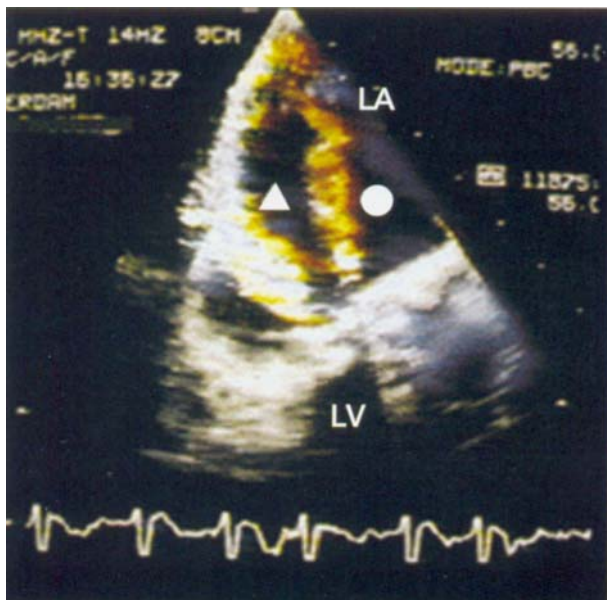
Transoesophageal echocardiographic colour Doppler flow image obtained in another patient with a St. Jude Medical prosthesis in the mitral position. Note the normal jet (white circle) caused by leakage backflow, and the bright, extensive jet (triangle) that arises outside the prosthetic valve ring (paraprosthetic regurgitation jet). LA = left atrium, LV = left ventricle. (Reproduced from Van den Brink *et al.* 1989,¹⁰ with permission from Excerpta Medica Inc., and the first author.)
